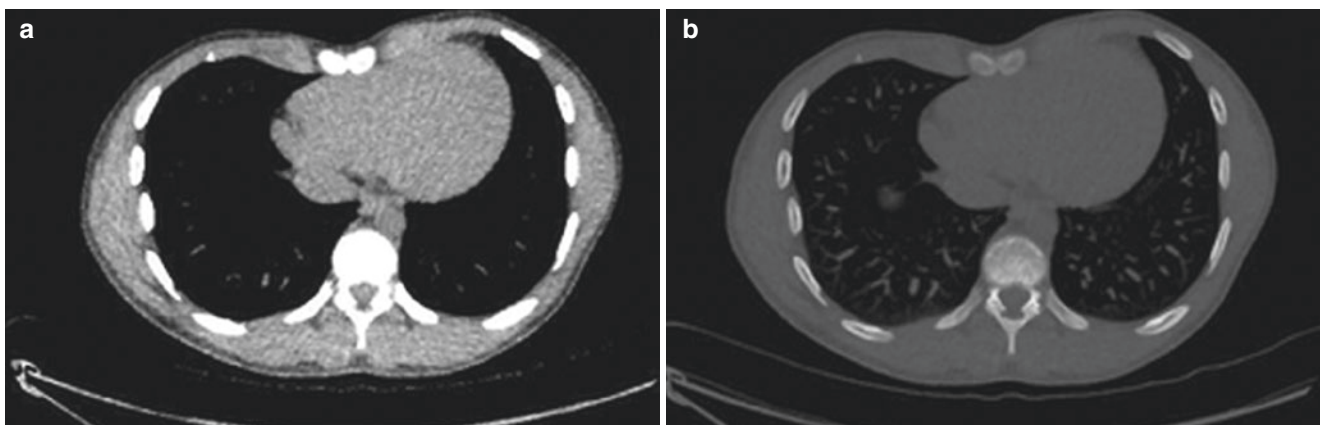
(a, b) Axial CT views of the chest in a patient with pectus excavatum, low-dose protocol with soft tissue (a) and bone (b) windows. There is significant image noise seen in the soft tissues of the chest wall
